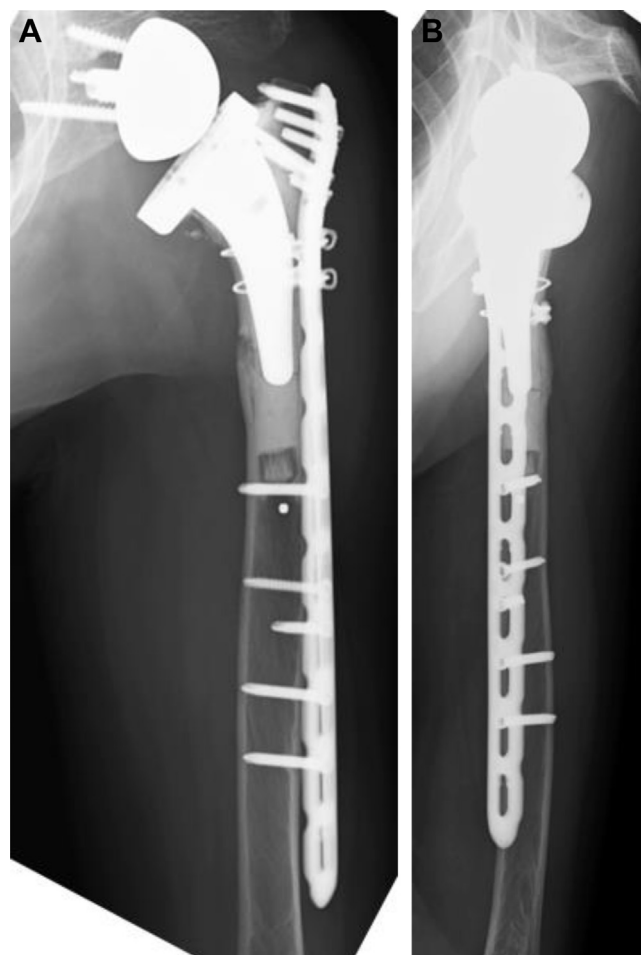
(A) Anteroposterior radiograph taken at final follow-up 6 months postoperatively. (B) Lateral radiograph taken at final follow-up 6 months postoperatively.
